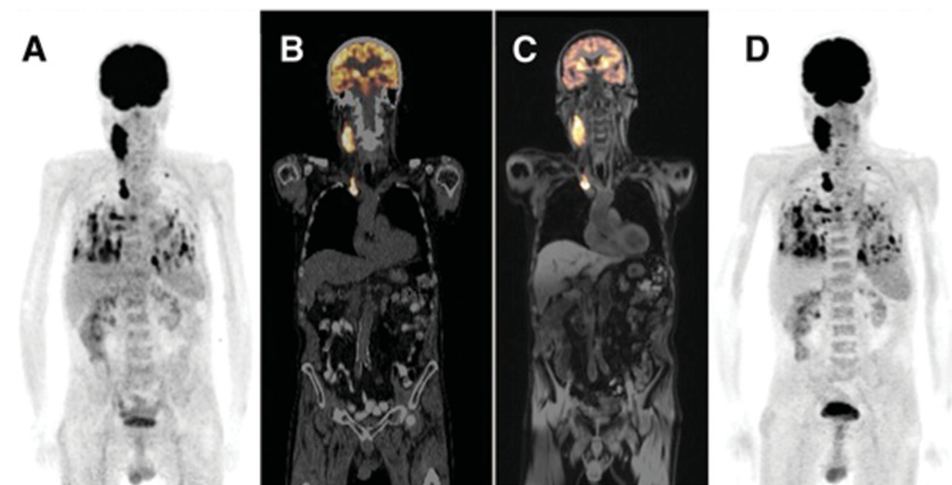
Similarity of PET/CT and PET/MRI scans, acquired on the same day in the same patient with metastasized thyroid carcinoma. A) ^{18}F -FDG PET acquired on PET/CT scanner. B) Overlay of PET (in orange) and structural low-dose CT data acquired on a PET/CT scanner. C) Overlay of PET (in orange) and MRI acquired on PET/MR scanner. D) ^{18}F -FDG PET acquired on PET/MR scanner. An overall similarity can be seen in pattern of suspicious lesions in (A) and (D). Adapted with permission.^[78] Copyright 2012, Society of Nuclear Medicine and Molecular Imaging.
